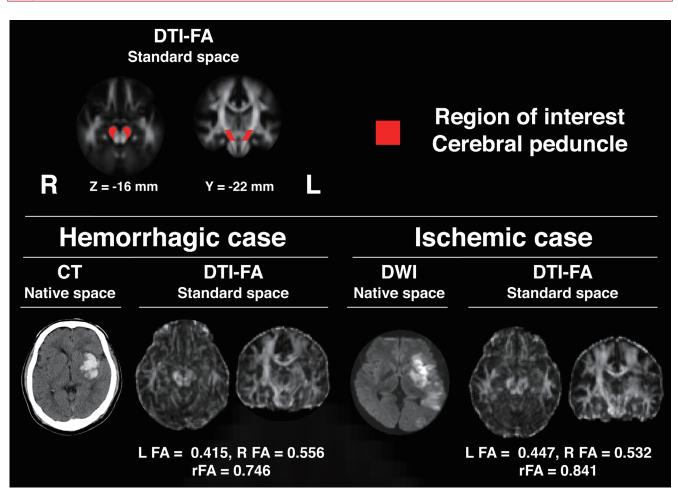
Regions of interest in cerebral peduncles and examples of DTI-FA images from a patient with hemorrhagic stroke and a patient with ischemic stroke transformed into the standard space. CT, computed tomography; DWI, diffusion-weighted imaging.
